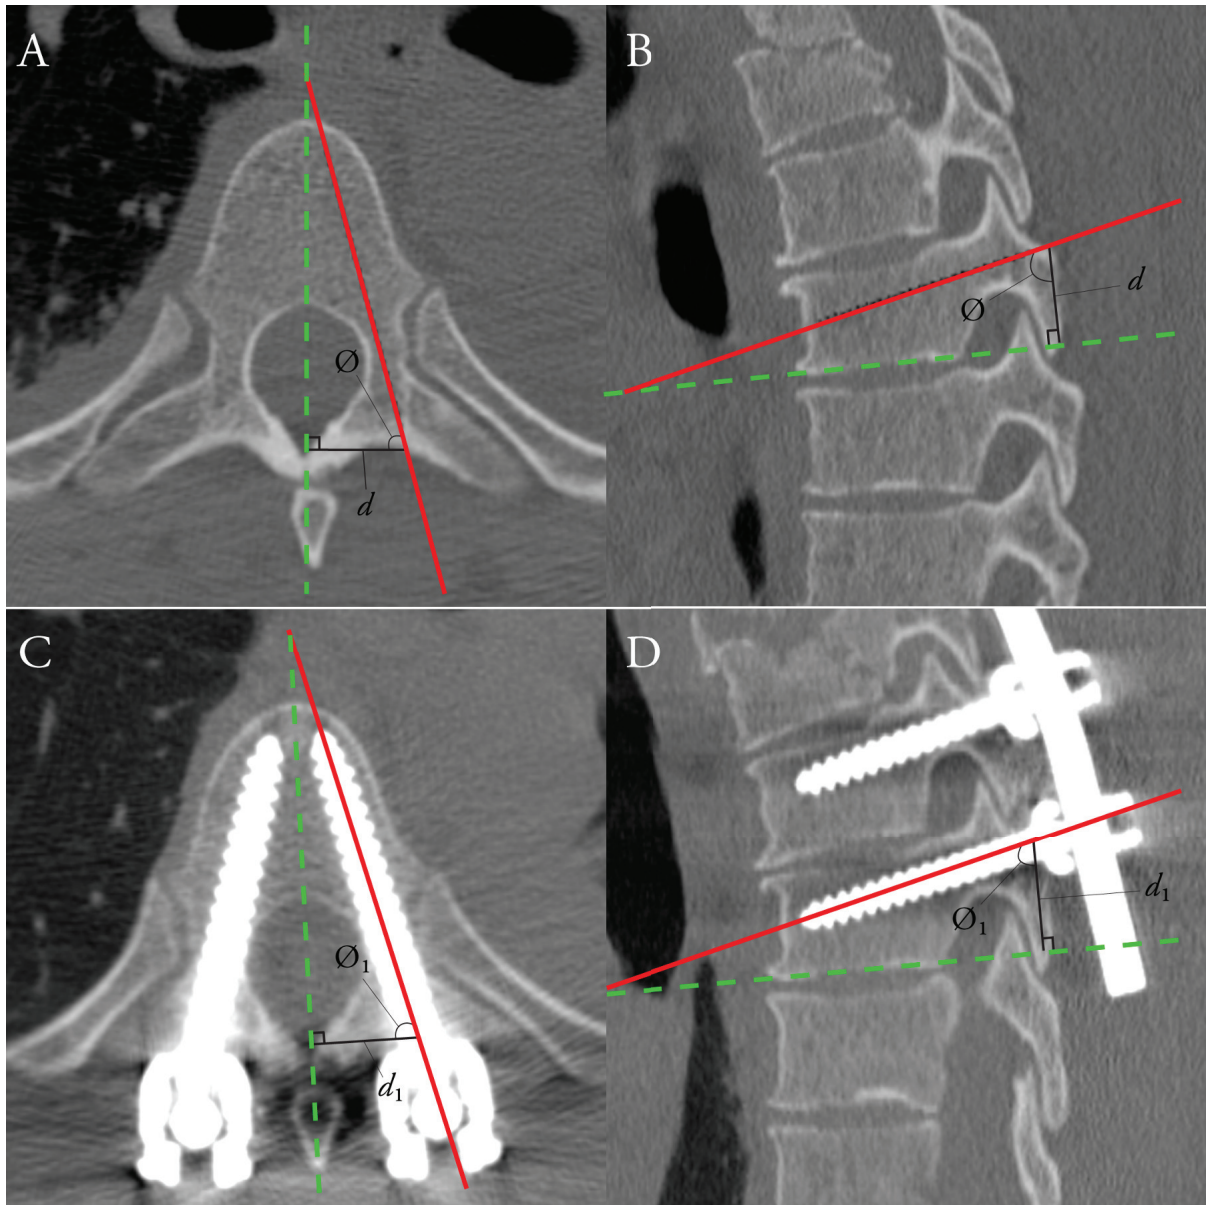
Absolute navigation accuracy: Measurement of absolute navigation accuracy, in the axial (A+C) and sagittal (B+D) planes. Comparison is made between intra-operative navigation screenshots of planned entry points and trajectories (A+B), to final screw placement on post-operative CT (C+D). Reference lines (dashed) are drawn, in the axial plane, in the mid-sagittal line (bisecting the vertebral body, spinal canal and spinous process) and, in the sagittal plane, along the inferior endplate. Translational error is computed as  $(d_1 - d)$ ; angular error is computed as  $(\phi_1 - \phi)$
